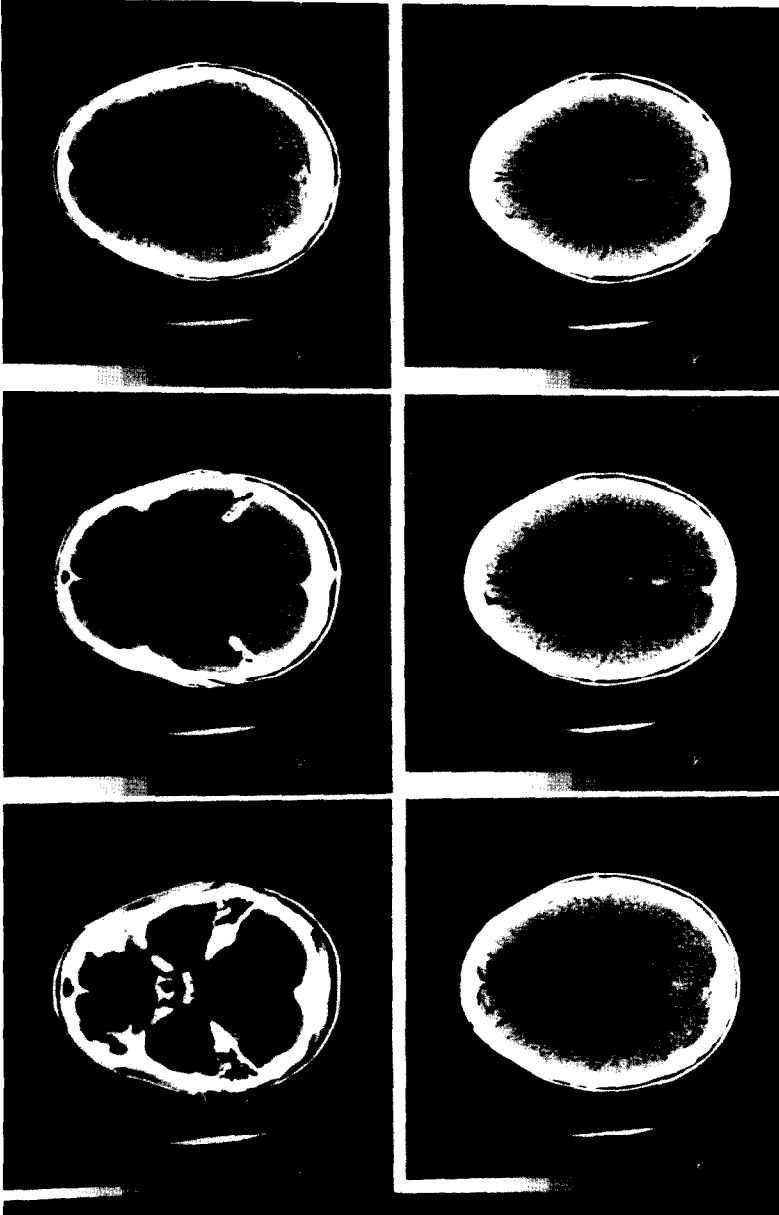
CT scan of Patient JC, demonstrating low density defects in the orbitomedial frontal lobes bilaterally.
